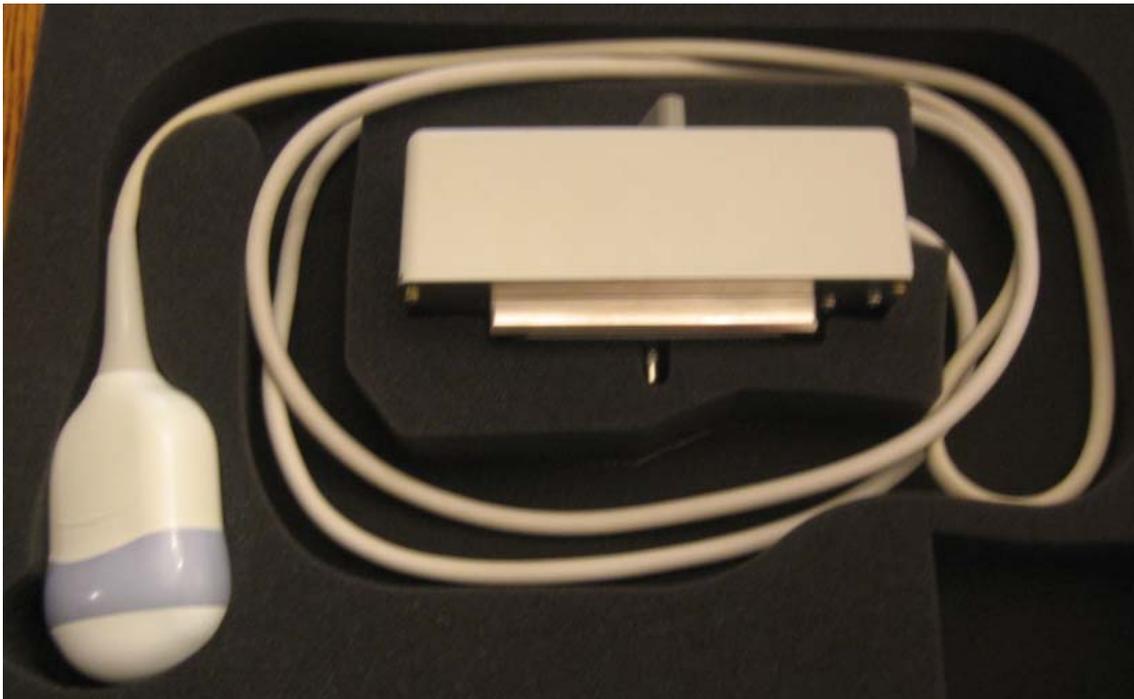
Ultrasound transducer. This functioning ultrasound transducer, used in the Duke Fetal Diagnostic Center, served as the model for the control and interventions used in the current study. The transducer is one unit as shown; the cable cannot be detached from the large box-like unit for connection to the ultrasound machine.
